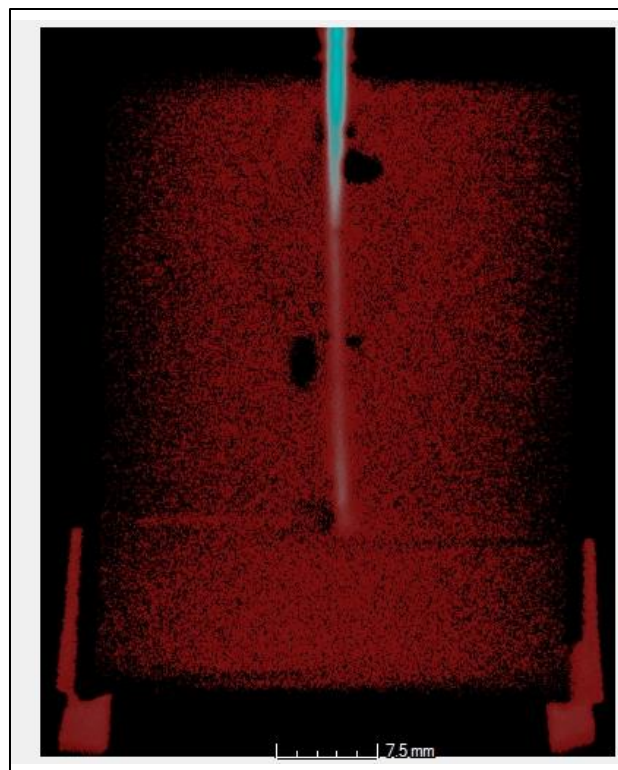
X-ray image of balloon filled with water inside a hydrogel sample.
